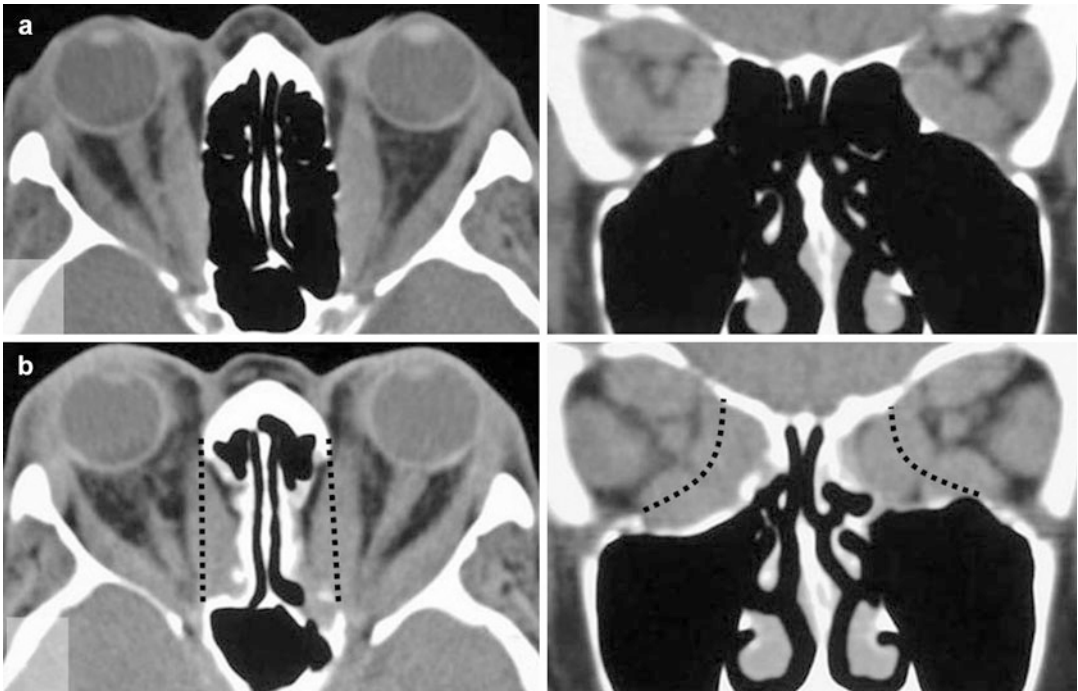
(a) Axial and coronal CT images of patient with bilateral proptosis and severe thyroid optic neuropathy, these showing crowding of the optic nerves particularly at the orbital apices. (b) After infero-medial orbital
